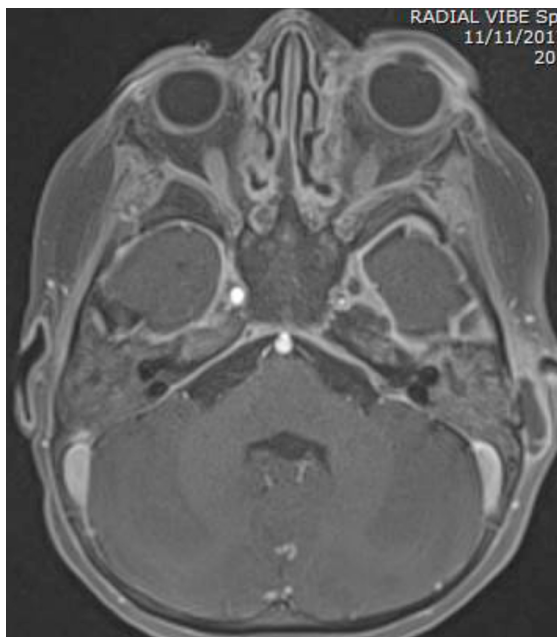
MRI Brain demonstrates evidence acute left mastoiditis with accompanying abscess of the left periauricular soft tissues. Intracranial extradural extension with abscess formation deep to the left sigmoid sinus. Features of secondary skull base osteomyelitis with an abscess underlying the left skull base. Near complete left cavernous sinus and left superior ophthalmic vein thrombosis with marked venous congestion of the left intra-orbital and periorbital soft tissues. Mural thickening and luminal narrowing of the left internal carotid artery.
